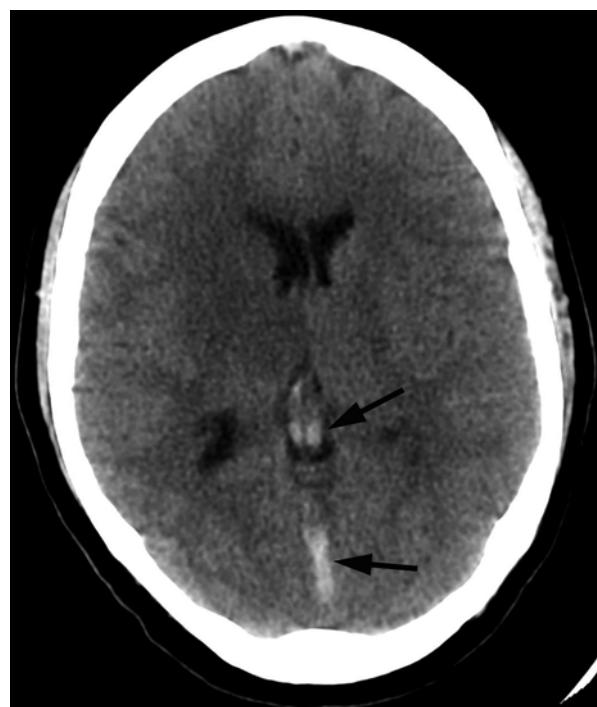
CT showing high attenuation thrombus within distended internal cerebral veins and straight sinus (arrows) and low attenuation within the right lentiform nucleus, caudate head and thalamus on the right
